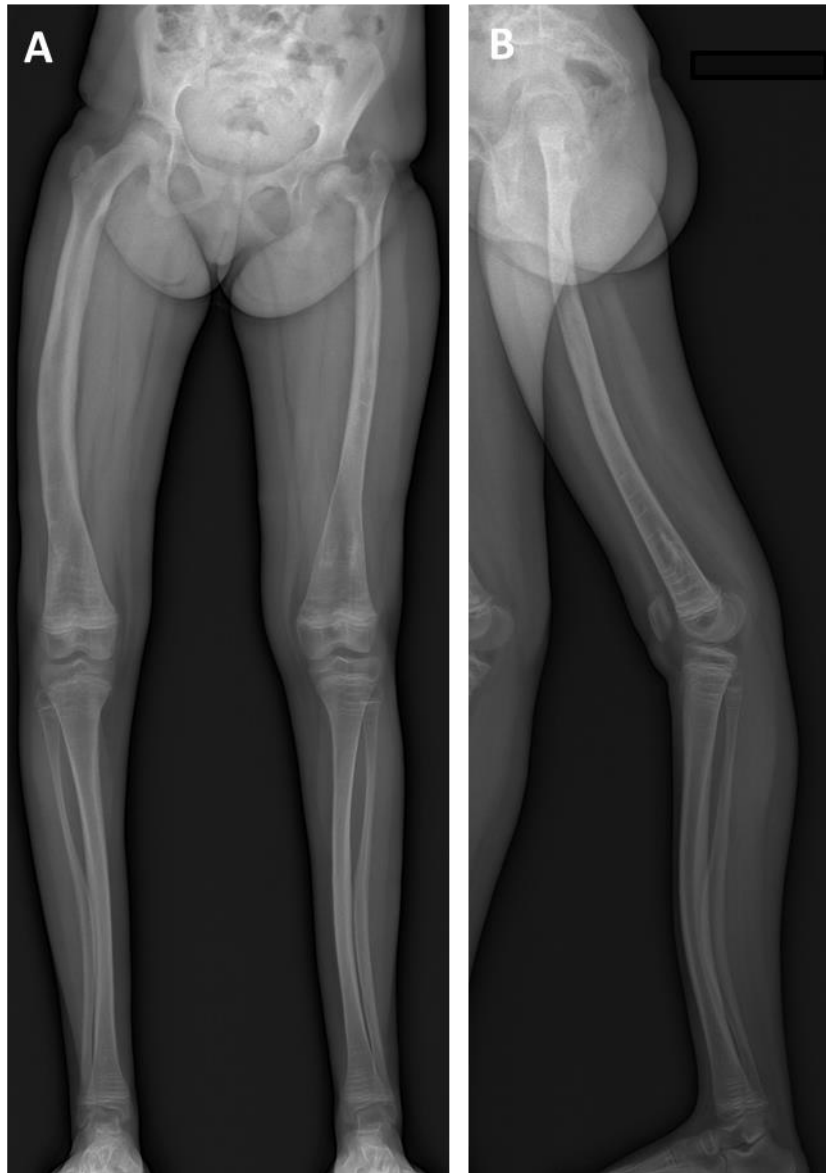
Lower limb X-ray of Patient B.II.4 at 15 years old showing abnormalities of the bone remodeling with femoral deformation, bone demineralization and Left Coxa vara.
